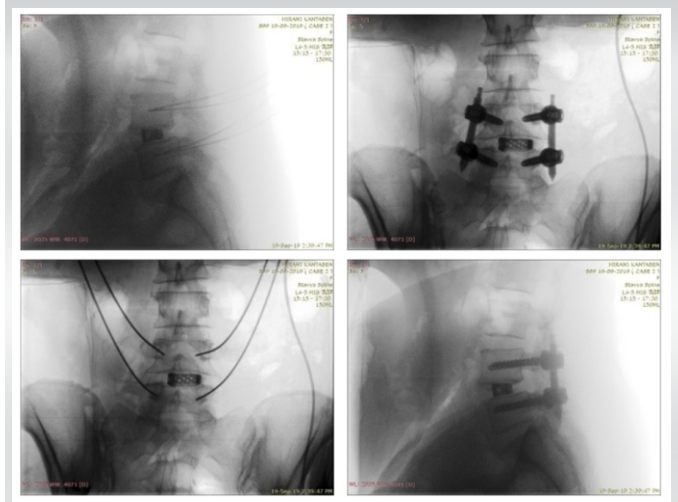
The images on the left are AP and lateral views after inserting cage and guidewire. The image on the right shows the final X-ray picture after TLIF.
